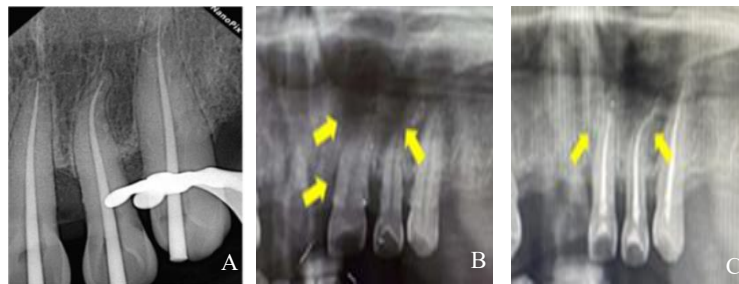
Radiographic image of root canal treatment of teeth 21,22,23 (Conservation Department). A) Post obturation radiographic image. B) Pre-treatment radiographic image. C) Radiographic image after treatment.
